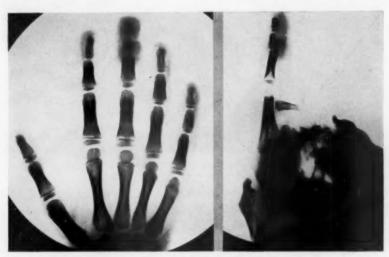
Roentgenogram of the fingers, six weeks after the initial transplantation, showing the inflammatory thickening of the transplant.
